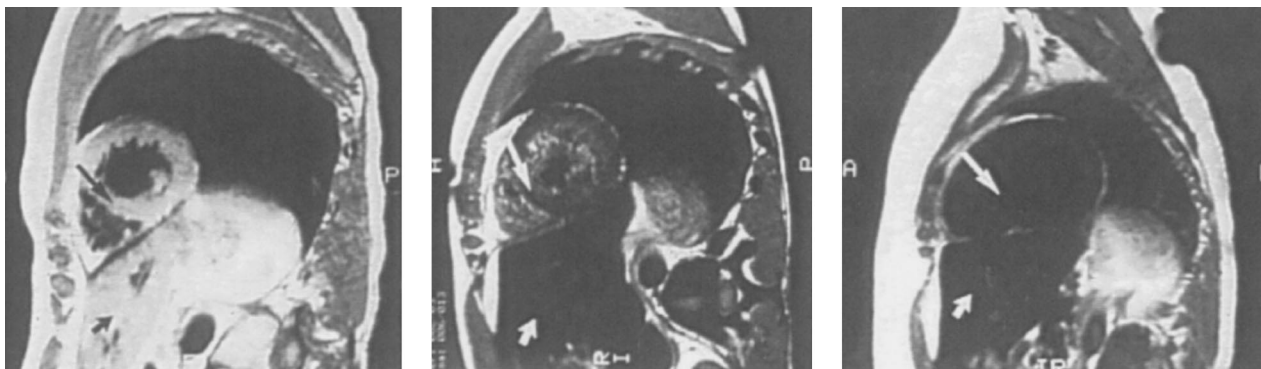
Sagittal MRI of the heart in three patients with homozygous β thalassemia and transfusional iron overload. (A, left) Normal signal from the septum (long arrow) and posterior wall of the heart, consistent with the presence of very mild cardiac iron loading, in a transfused patient regularly compliant with iron chelating therapy. The homogenous signal of the liver, consistent with very mild iron loading in this organ (short arrow), is also seen below the image of the heart. (B, middle): Inhomogeneity of signal from the septum (long arrow) and posterior wall, consistent with moderate iron deposition in a transfused patient erratically compliant with iron chelating therapy. Loss of liver signal (short arrow) is consistent with heavier iron loading in this organ. (C, right): Absence of signal from the septum (arrow), posterior wall and liver (short arrow), compatible with heavy iron deposition in a transfused patient who has been noncompliant with iron chelating therapy over several years.
